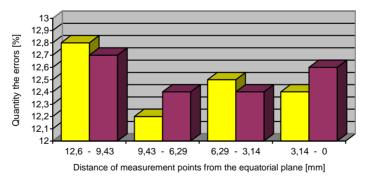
Histogram of the distribution of the measuring results on CT at some distance of measurement points from the equatorial plane.
